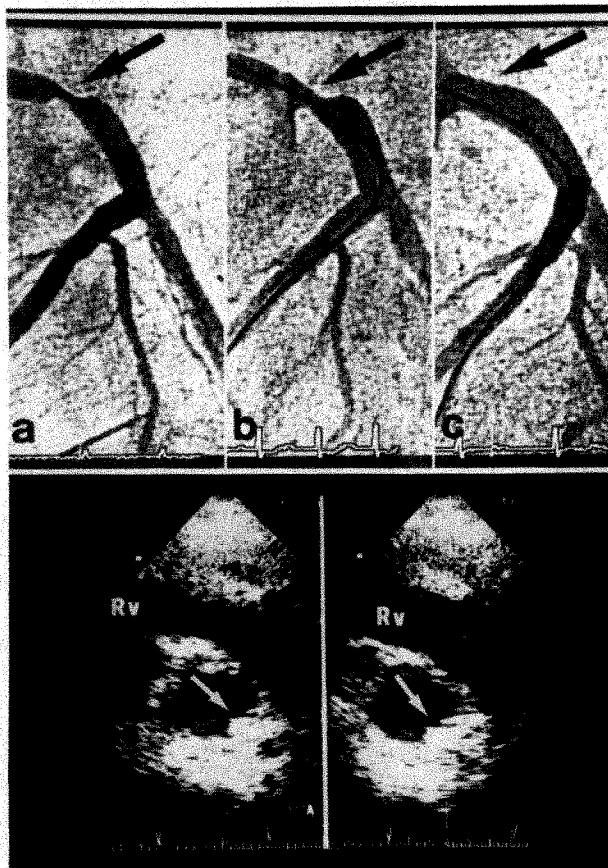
a*, left anterior oblique (45°) projection with cranial (20°) angulation revealing a severe stenosis in the ostium of the left main coronary artery (arrow). *b*, after conventional percutaneous transluminal coronary angioplasty significant (55%) residual stenosis persists. *c*, no significant residual stenosis is appreciated after coronary stenting. Bottom, echocardiographic study from the short-axis parasternal view of the aortic root just above the aortic valve cusps. A bright echodense structure protruding into the aortic root is shown at the 4 o'clock position (arrow). This image remained unchanged despite the use of slightly oblique cuts. Rv = right ventricular outflow tract.
